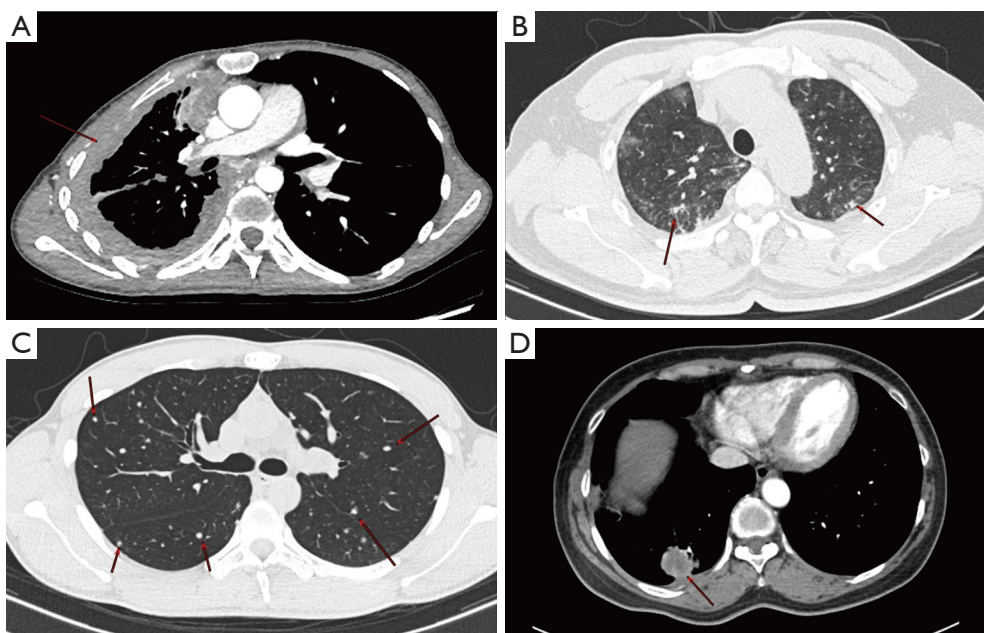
Four imaging classifications of PEH according to the consensus. (A) Female, 28 years old, chest enhancement CT scan, mediastinal window cross-section shows diffuse uneven thickening of the right pleura (arrow). (B) Male, 52 years old, chest CT scan, lung window cross-section shows a multifocal fine reticular and nodular faint shadow in both lungs (arrow). (C) Male, 21 years old, chest CT scan, lung window cross-section shows multiple solid nodular shadows in both lungs (arrow). (D) Female, 55 years old, chest enhancement CT scan, mediastinal window cross-section shows a mass shadow in the posterior basal segment of the right lower lung, involving the right lower pleura (arrow). PEH, pulmonary epithelioid hemangioendothelioma; CT, computed tomography.
